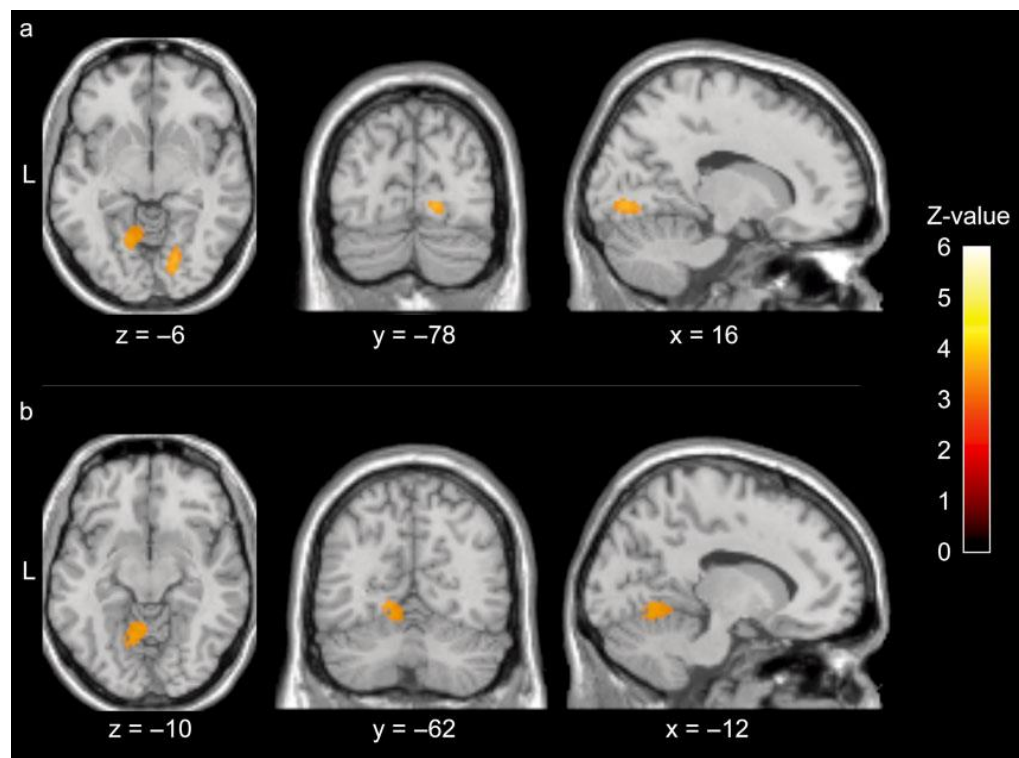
Areas of increased metabolism in the right lingual gyrus (a) and anterior lobe of the left cerebellum (b) in patients with visual snow, measured through [^{18}F]-FDG PET.
